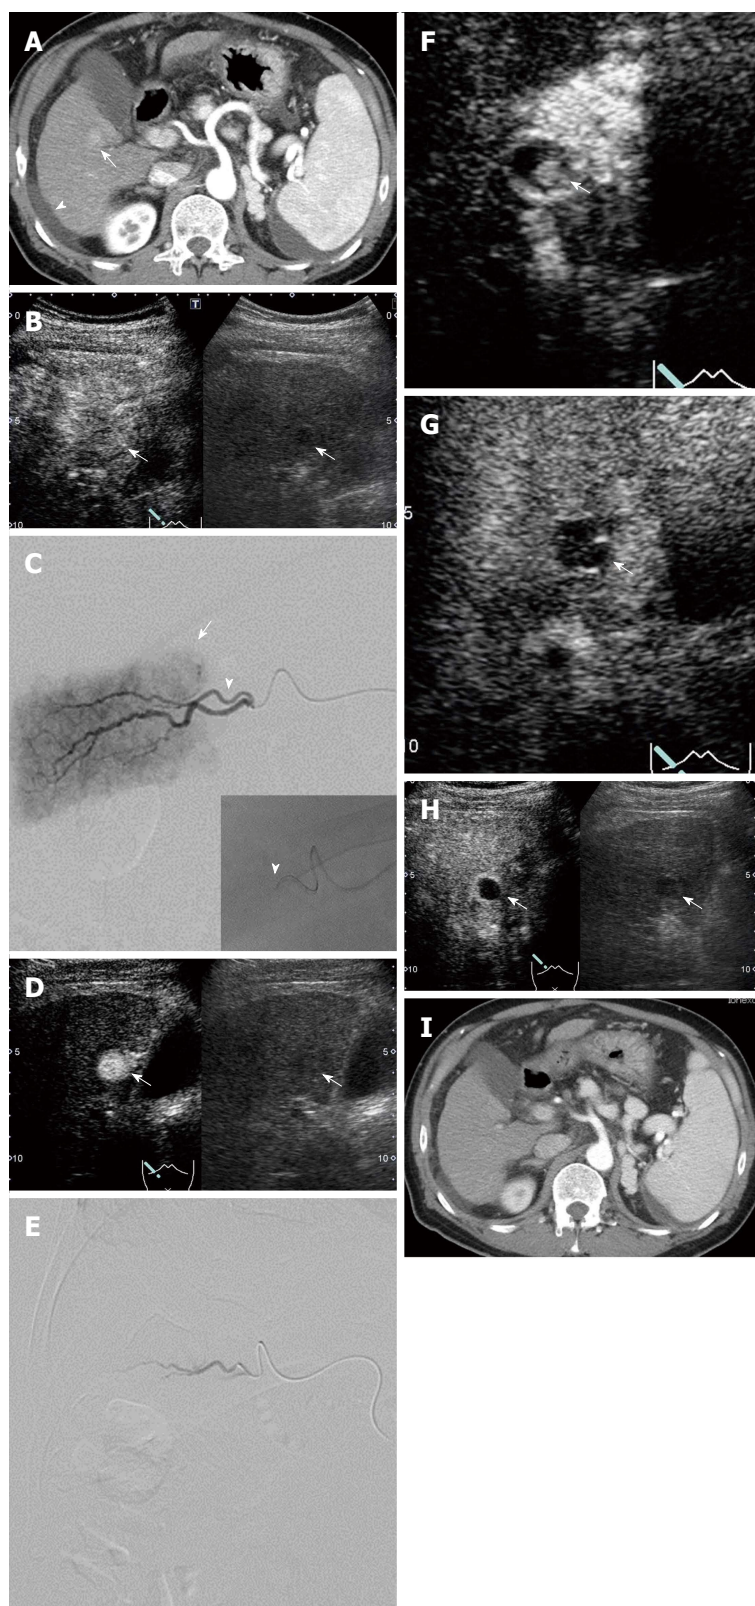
The patient was a 59-year-old male with alcoholic liver cirrhosis. DEB-TACE and transcatheter CEUS (IAUS) using Sonazoid for HCC in S5 with a diameter of 15 mm were performed. A: Dynamic CT in the arterial phase before DEB-TACE showed a hypervascular lesion in S5 (arrow) and ascites (arrow head); B: CEUS in the arterial phase (40 s) before DEB-TACE showed a hyperenhanced lesion in S5 (arrow) (Right image: Monitor mode); C: Digital subtraction angiography (DSA) from a branch of A6 (arrow head) before DEB-TACE showed tumor enhancement (arrow). Insert image: A coaxial microcatheter was advanced in the feeding artery (arrow head); D: IAUS from the branch of A6 before DEB-TACE showed a hyperenhanced lesion (arrow). (Right image: monitor mode); E: DSA from A6 after DEB-TACE (when contrast medium disappeared from the blood vessel within 5-6 heart beats) eliminated the tumor enhancement; F: IAUS from A6 after DEB-TACE showed a residual hyperenhanced area in the tumor (arrow) in spite of elimination of tumor enhancement by DSA. Therefore, DEB-TACE for this lesion was performed repeatedly until the hyperenhanced area disappeared; G: IAUS from the right hepatic artery eliminated the residual area in the tumor (arrow); H: CEUS in the arterial phase (40 s) showed unenhancement lesion in S5 three days after DEB-TACE (arrow) (Right image: monitor mode); I: Dynamic CT in the arterial phase did not show the hypervascular lesion six months after DEB-TACE.
